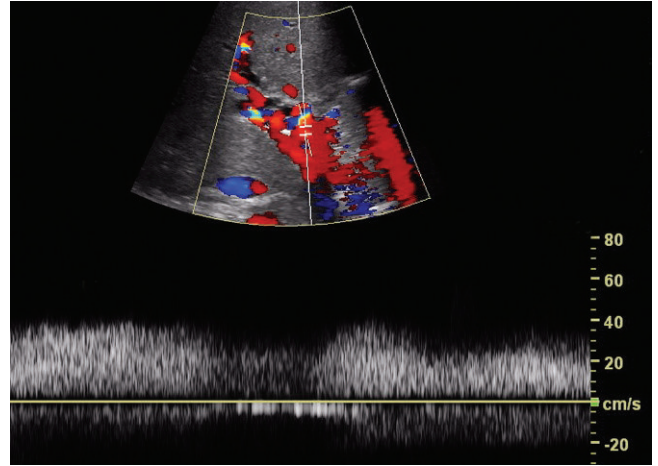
The Doppler waveform confirms that the tubular collaterals in the porta have venous flow.
